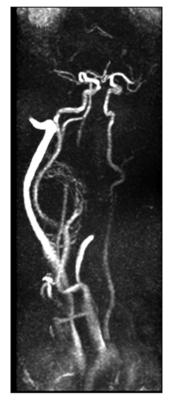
A mass localized to right carotid bifurcation as it displaced the internal carotid artery posteriorly and the external carotid artery anteriorly on angiography with MRI.
